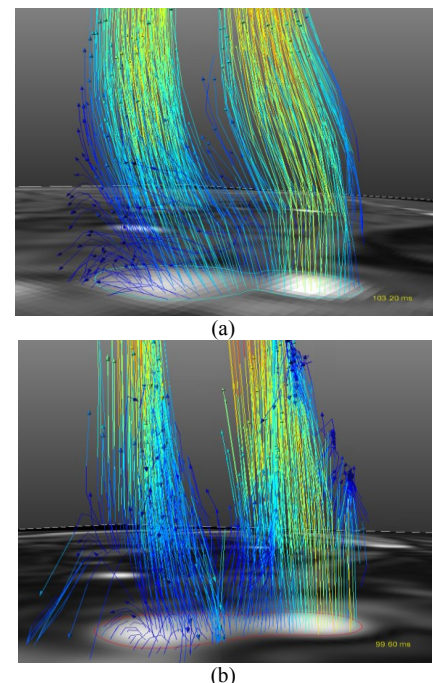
Flow pathlines systolic cardiac phase in right carotid artery acquired using (a) conventional 4D Cartesian PC MRI and (b) 4D spiral PC MRI
